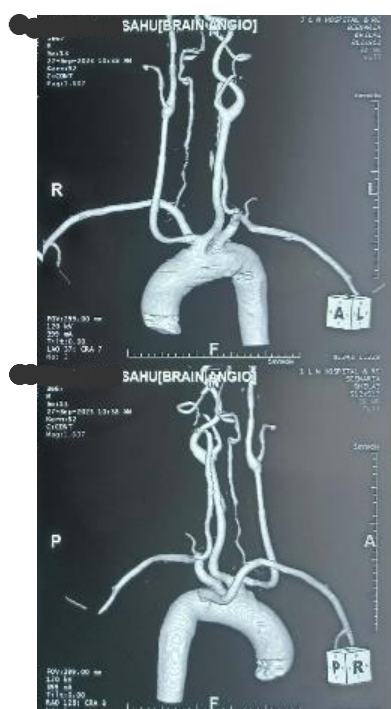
3D CT Angiography image exposed an aberrant right subclavian artery
